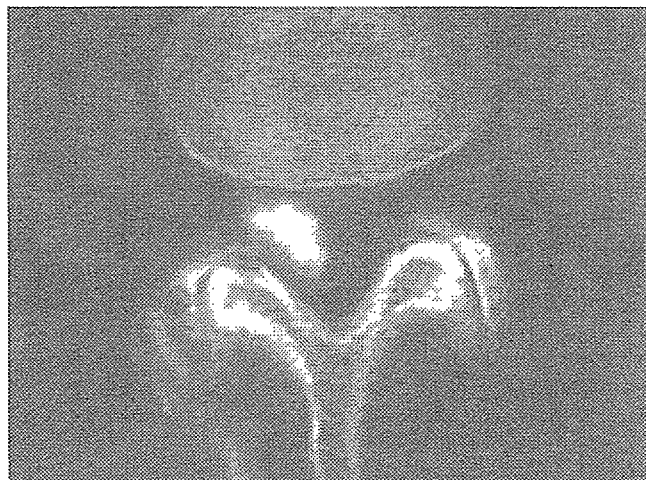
Axial CT scan obtained after facet joint arthrography. The contrast medium clearly helps to delineate the communication between the juxtafacet cyst and neighboring facet joint.
